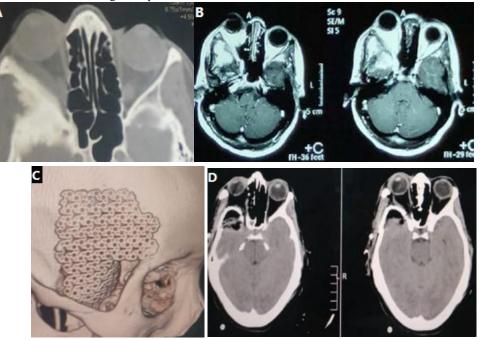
radiology of patient in figure 2. A, B: CT skull bine window and MRI brain showing proptosis and hyperostosis. C, D: post-operative CT skull 3D and brin denoting the pattern of mesh reconstruction and proptosis improvement.
